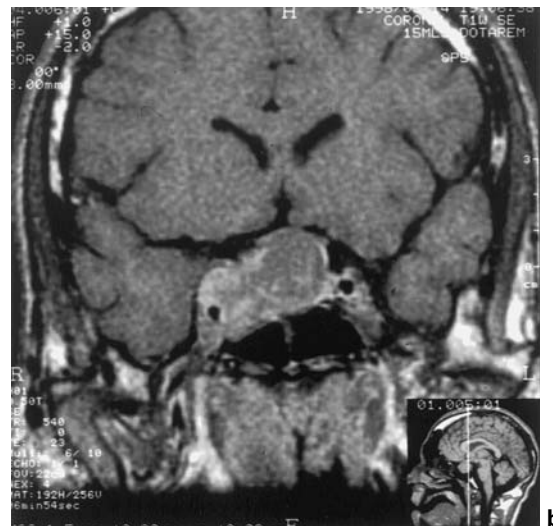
a–b A large pituitary tumor compressing surrounding structures. a Sagittal MRI. b Coronal MRI.
